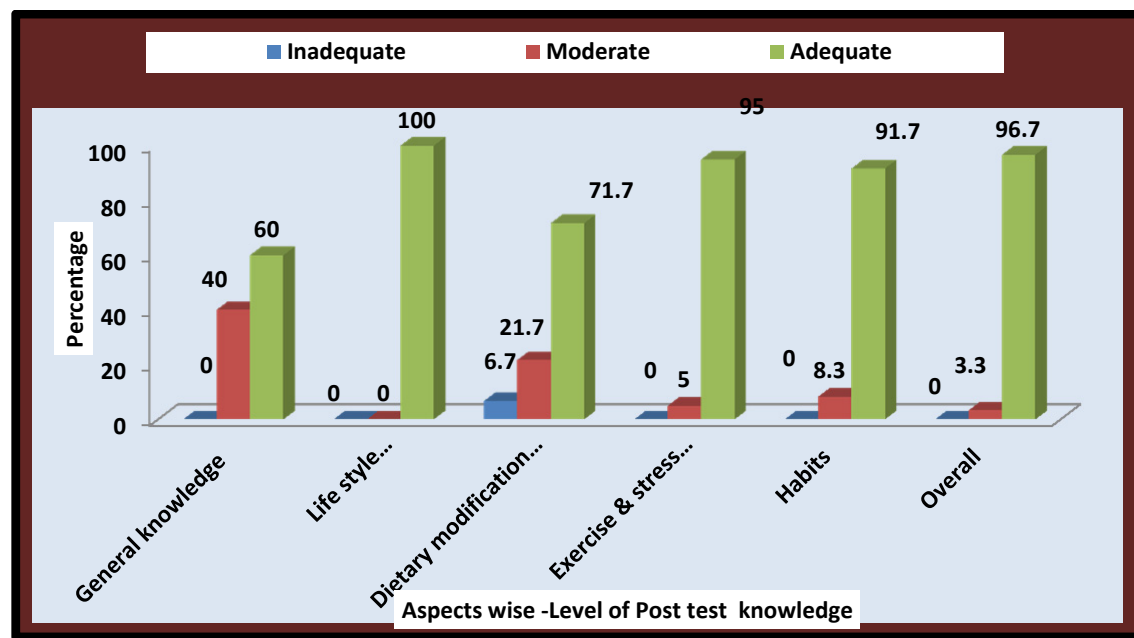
FREQUENCY AND ASPECT WISE POST TEST INTERVENTIONAL KNOWLEDGE
